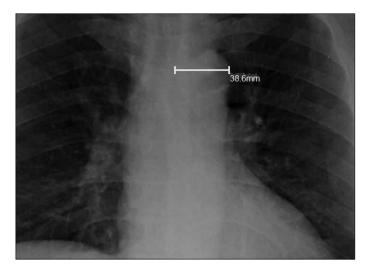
The aortic knob width on postero-anterior chest X-ray film
